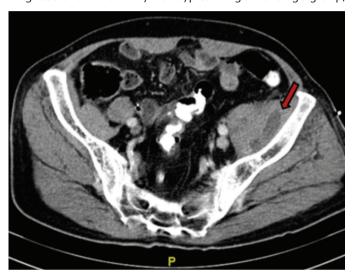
Psoas abscess in the transverse section of computed tomography image at the S2-S3 level
